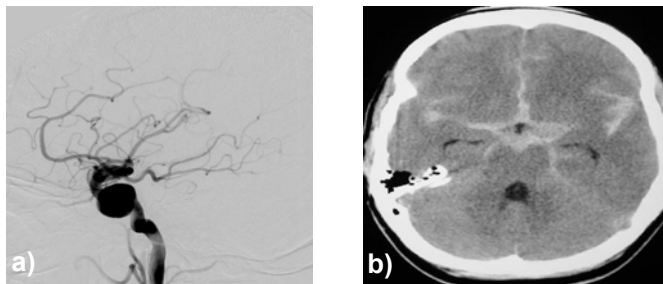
1 a) DSA image: Aneurysm of the right internal carotid artery. b) CT image of a subarachnoid hemorrhage. c) MRI images of the areas of the left and right middle cerebral arteries with magnetic resonance angiography images of the circle of willis.^[22]
